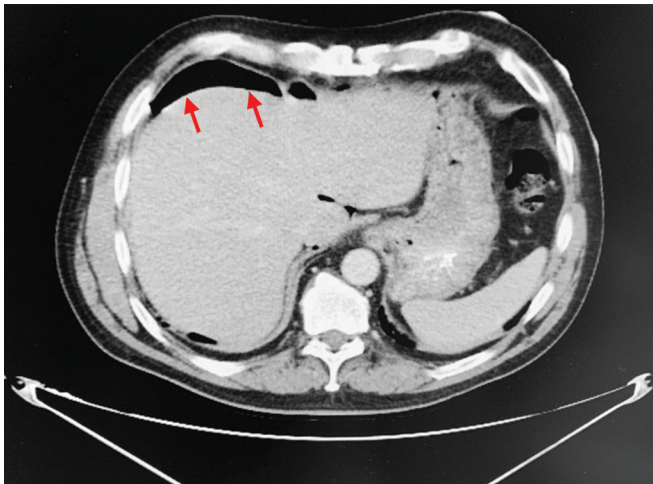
CT scan which demonstrated pneumoperitoneum at the red arrows
